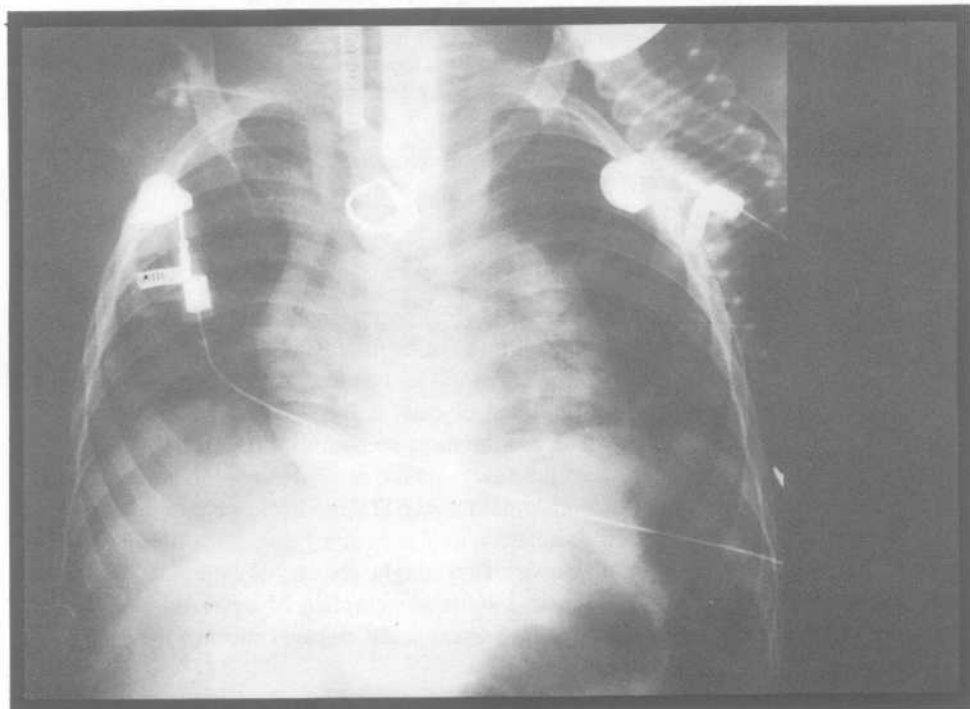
Plain x-ray of the chest showing the ring in the wall of the oesophagus. The endotracheal tube and the rigid oesophagoscope are also seen.
